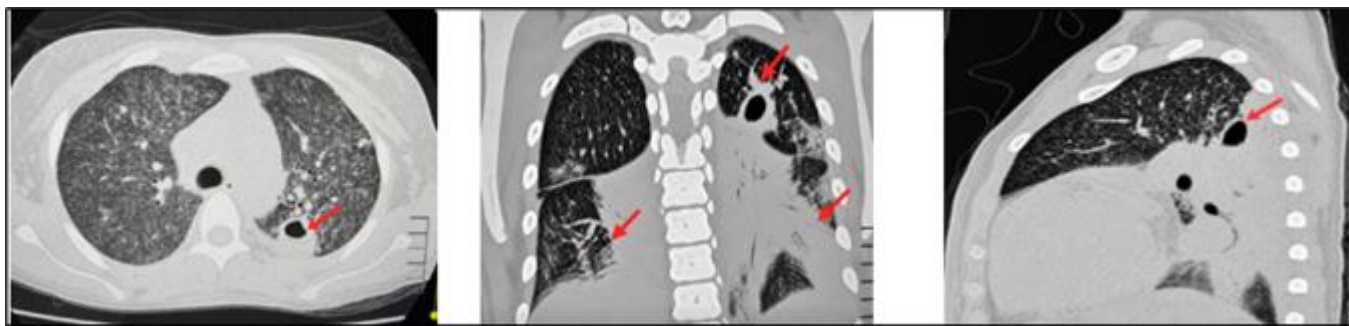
Computed tomography images of the chest in different planes, with evidence of cavitated pulmonary lesions and parenchymal infiltrates, indicated with red arrows, compatible with pulmonary involvement due to tuberculosis.
